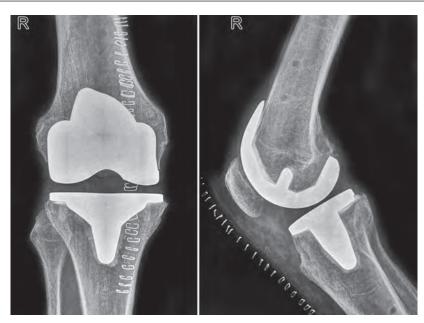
Postoperative anteroposterior and lateral X-ray of right knee
